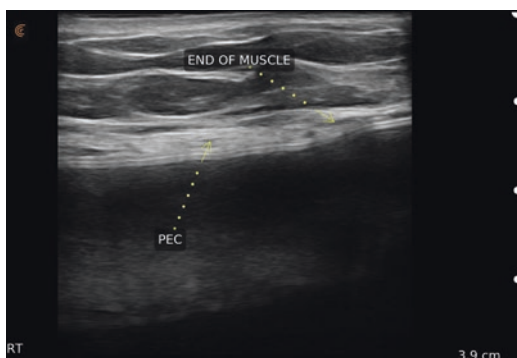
Grayscale ultrasound image of a breast implant imaged at the medial border of the implant at the level of the mid portion of the areola. The transition of the implant from the submuscular to the subglandular position is demonstrated
